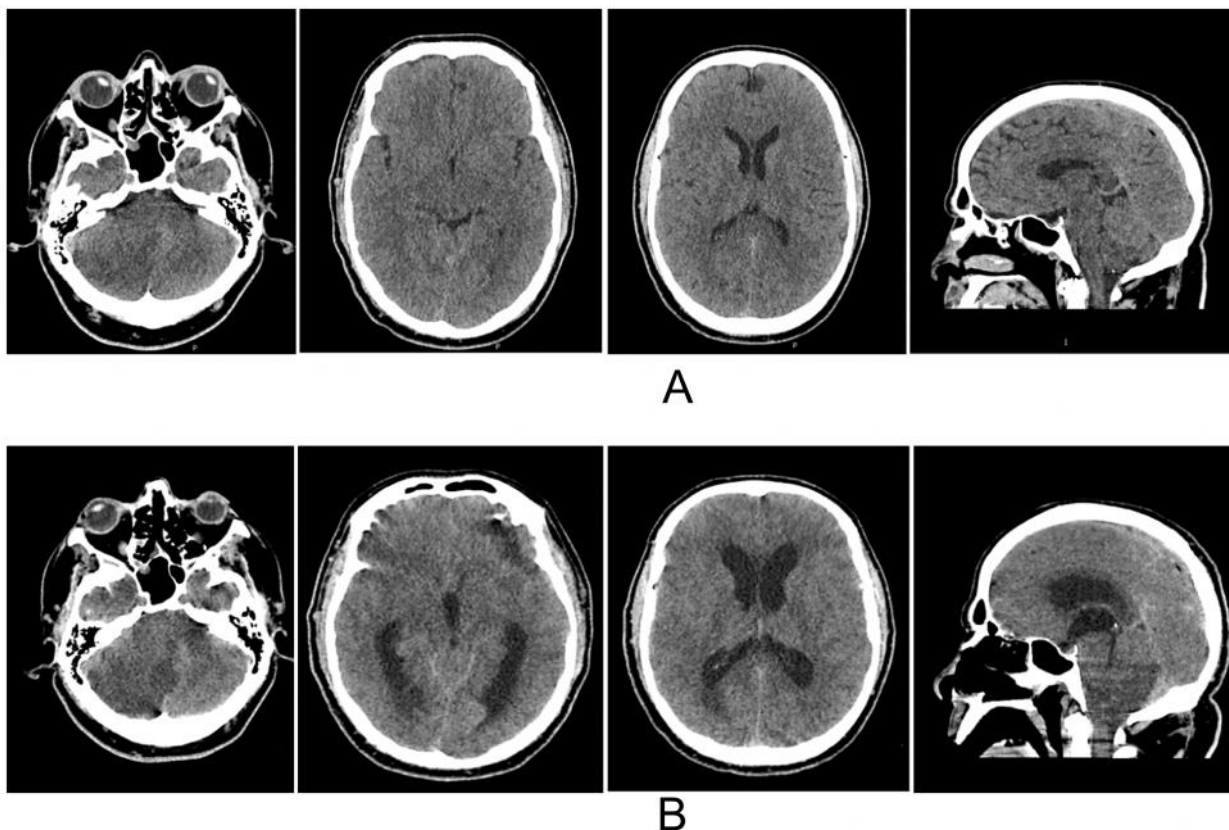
Computed tomography of the brain of a 46-year-old male patient P. with cerebellar malicioust myocardial infarction. A — 12 hours from the onset of stroke, GOS score 15, ischemia focus 52 cm³, moderate bilateral compression of the quadrigeminous cistern, obliteration of the IV ventricle, VBR2 — 13%, mass effect score 5 according to M. Jauss scale; B — 28 hours from the onset of the disease, GOS score 8, volume of the ischemia focus 98 cm³, obliteration of the quadrigeminous cistern and IV ventricle, significant expansion of the lower horns of the lateral ventricles, VBR2 — 23%, mass effect score 9 according to M. Jauss: significant direct compression of the brain stem on sagittal scans
